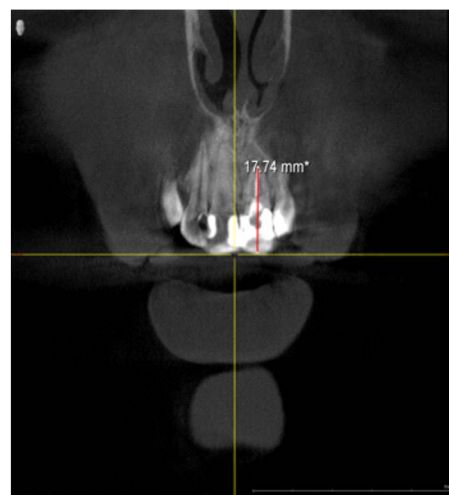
Working length confirmation on CBCT image
